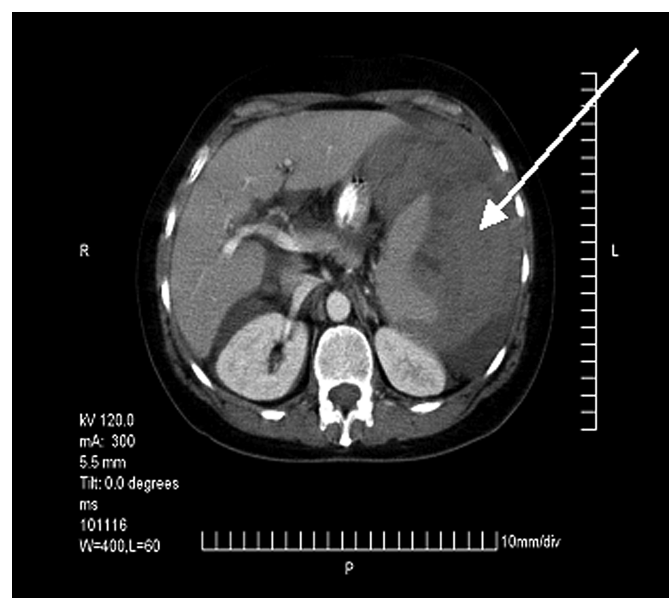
Transaxial computed tomographic scan image. The white arrow points to the 11 cm x 13 cm splenic hematoma.
